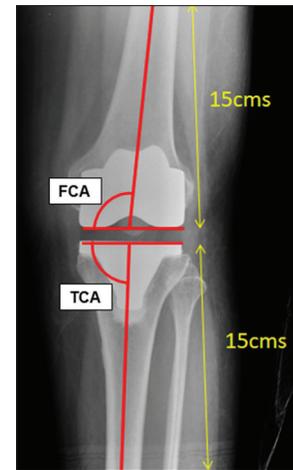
Femoral component angle (FCA) and tibial component angle (tca) measurement on conventional knee radiograph
